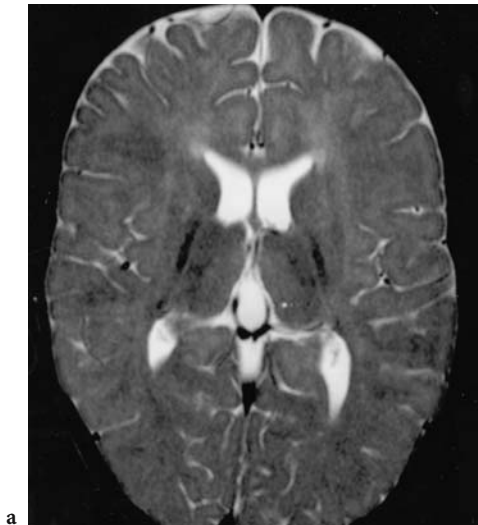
a Axial, b coronal T2 MRI of an 18-month-old girl with a clinical constellation compatible with Pelizaeus-Merzbacher disease. Minimal myelination of the posterior limb of the internal capsule and cerebellar white matter, otherwise almost no myelin
